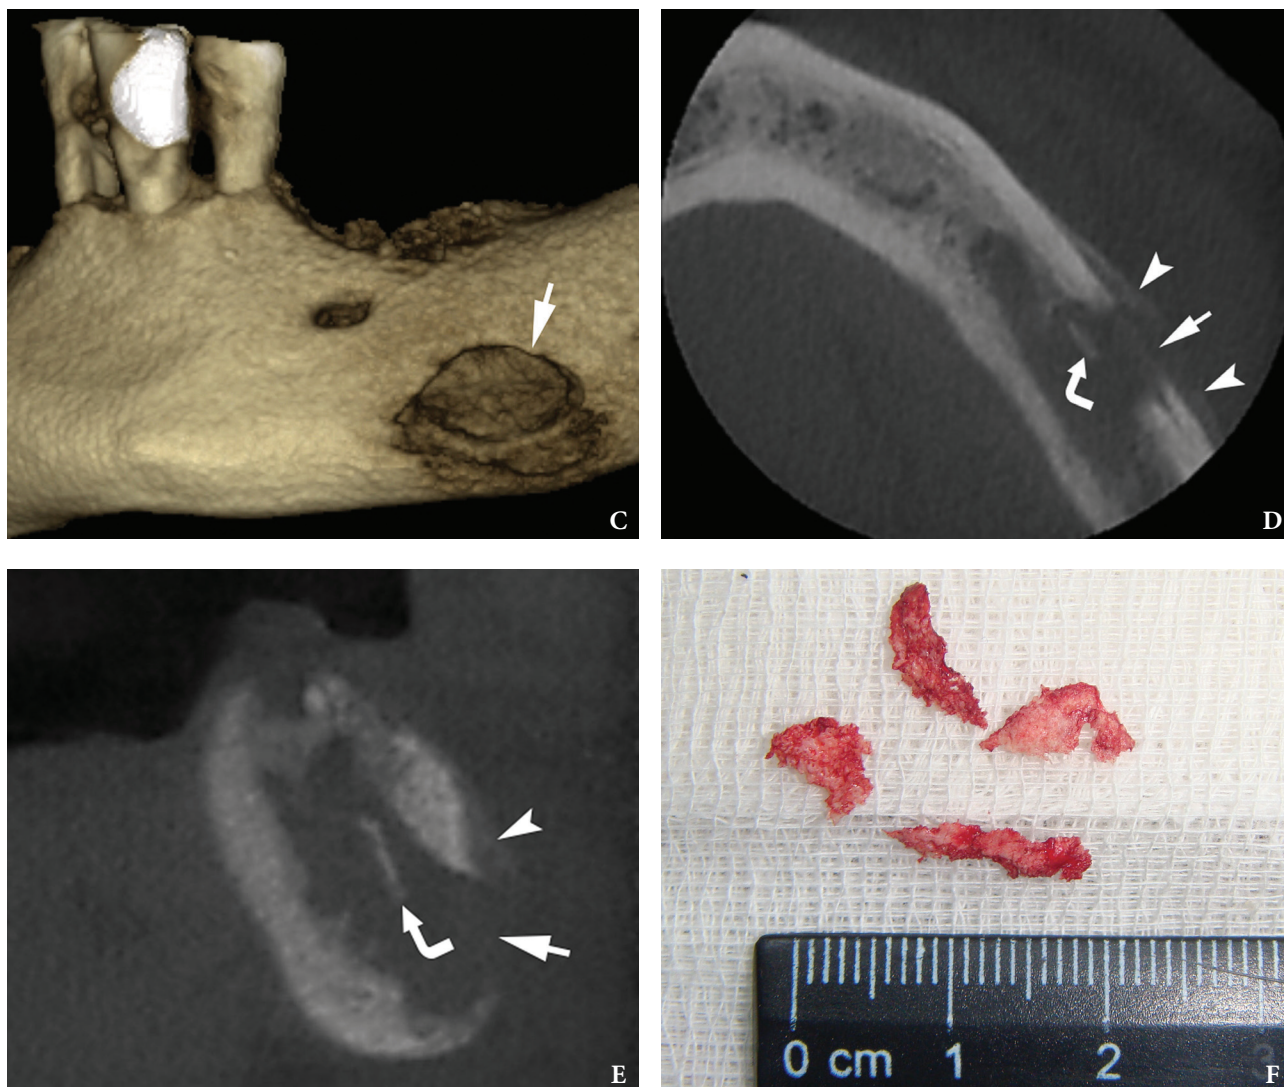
(cont'd). A 3D reconstructed (C), axial (D), and coronal (E) CBCT scans showed cortical bone defect (arrows). Sequestered bone fragment is indicated by curved arrow, periosteal reaction – by arrowheads. (F) Appearance of periosteal reaction after its removal. (Images of Figure 2 are courtesy of Ievgen I. Fesenko, Assis Prof, Kyiv, Ukraine)
